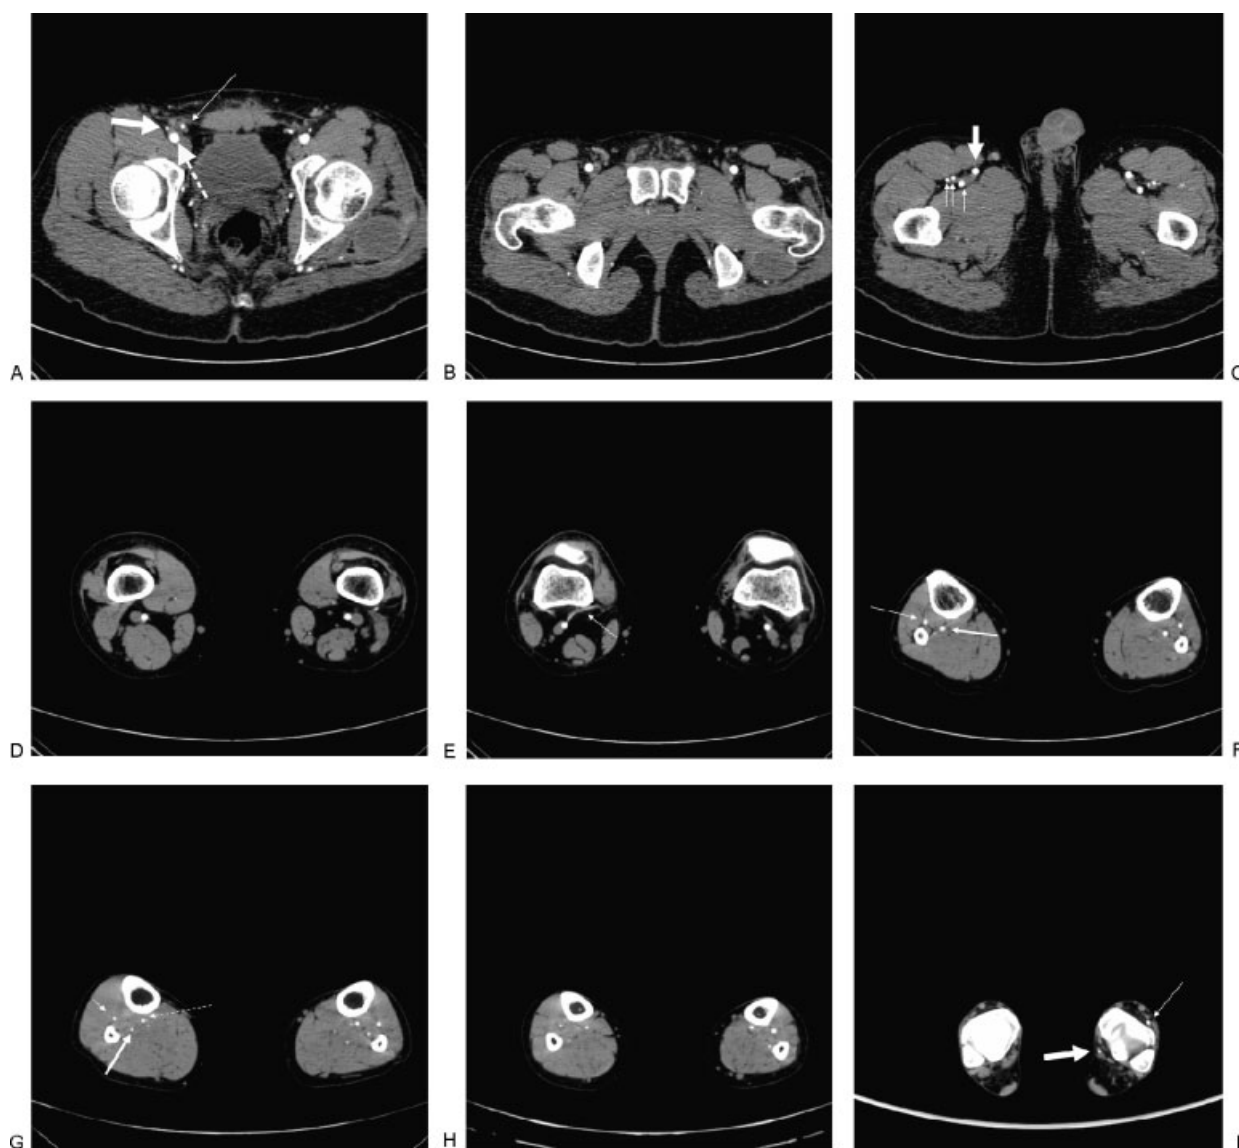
Axial arterial-weighted computed tomography images of normal arterial anatomy of leg. (A) Level of the upper common femoral artery in groin shows deep circumflex iliac artery (large arrow), inferior epigastric artery (small arrow), and common femoral artery (dashed arrow). (B) Level of lower common femoral artery in groin is shown. (C) Level of common femoral artery bifurcation in upper thigh shows branches of deep (profunda femoris) femoral artery (small arrows) and superficial femoral artery (large arrow). (D) Level of popliteal artery at the distal femur is shown. Note close approximation of popliteal artery (enhanced) and vein (unenhanced). (E) Level of popliteal artery at tibial plateau is shown. Note geniculate collateral artery (arrow). (F) Level of the trifurcation shows anterior tibial (AT) artery (small arrow) and peroneal–posterior tibial (PT) trunk (large arrow). (G) Level of trifurcation vessels in upper calf shows AT artery (small arrow), peroneal artery (large arrow), and PT artery (dashed arrow). (H) Level of trifurcation vessels in lower calf is shown. (I) Level of the ankle mortis shows PT artery (large arrow) and dorsalis pedis artery (continuation of AT artery) (small arrow).
